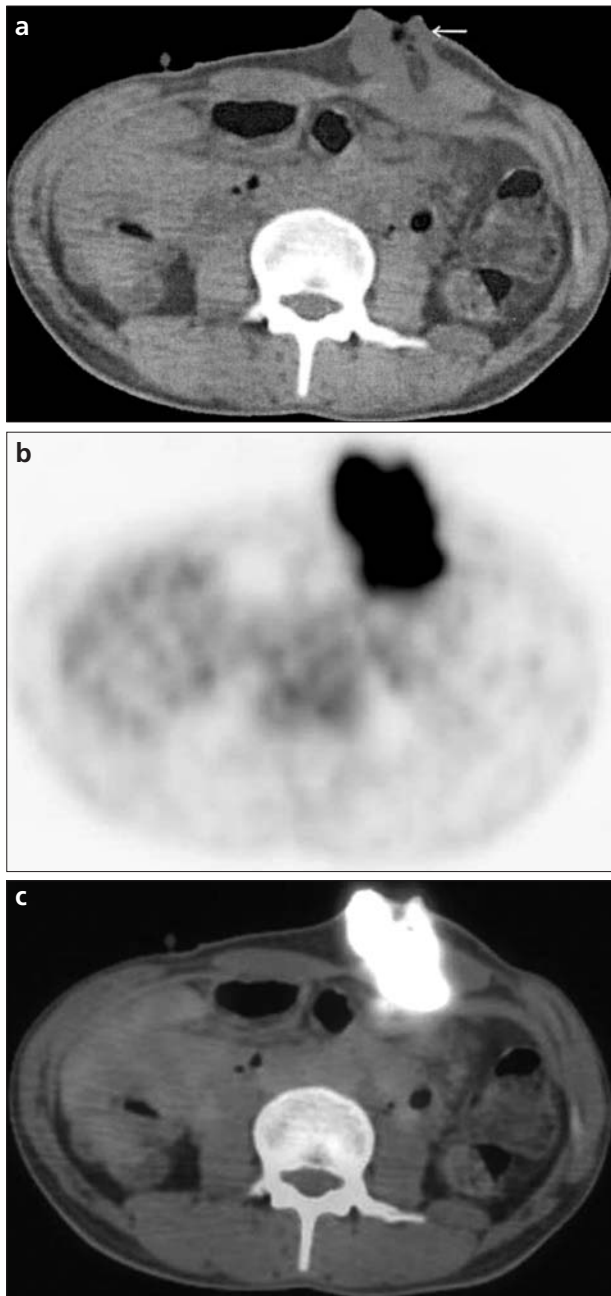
a-c. 50-year-old woman operated for squamous cell carcinoma of the tongue who had an ulcerated bleeding mass at the percutaneous endoscopic gastrostomy (PEG) site. Biopsy revealed metastasis. Non-contrast-enhanced CT (a) shows a soft tissue mass at the PEG site in the anterior abdominal wall (arrow). PET image (b) shows intense FDG uptake corresponding to the soft tissue at the PEG site. Combined functional and morphological information seen on fusion PET-CT image (c).
